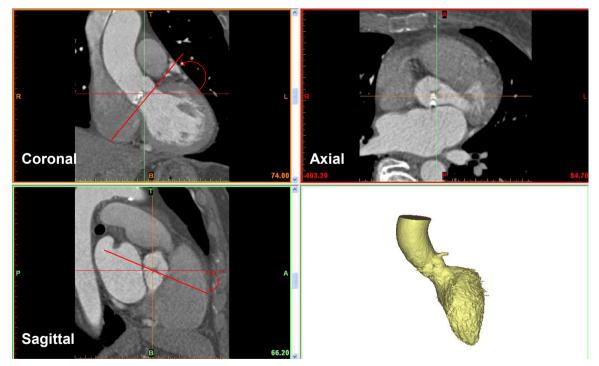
Figure CTA-2: Example images in original orientation (axial, coronal and sagittal). Red curved arrow and line indicate adjustment of coronal and sagittal planes to align with aortic basal annulus.
